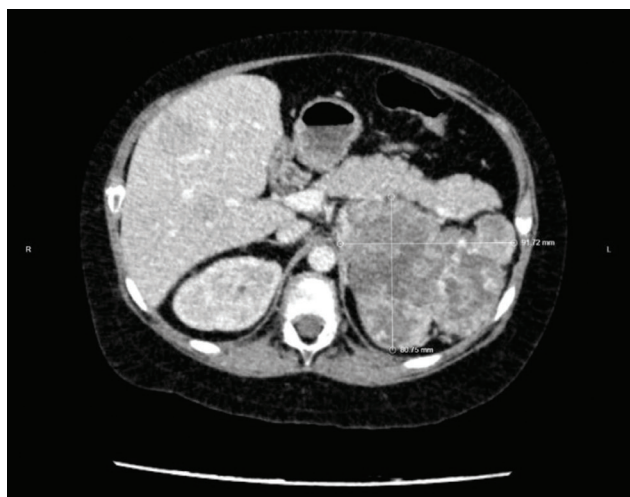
Thoracic, abdominal and pelvic CT revealed a large lobulated, heterogeneously enhancing left adrenal mass (8.1 x 9.3 x 8.7 cm) causing significant mass effect, including inferior displacement of the left kidney.
